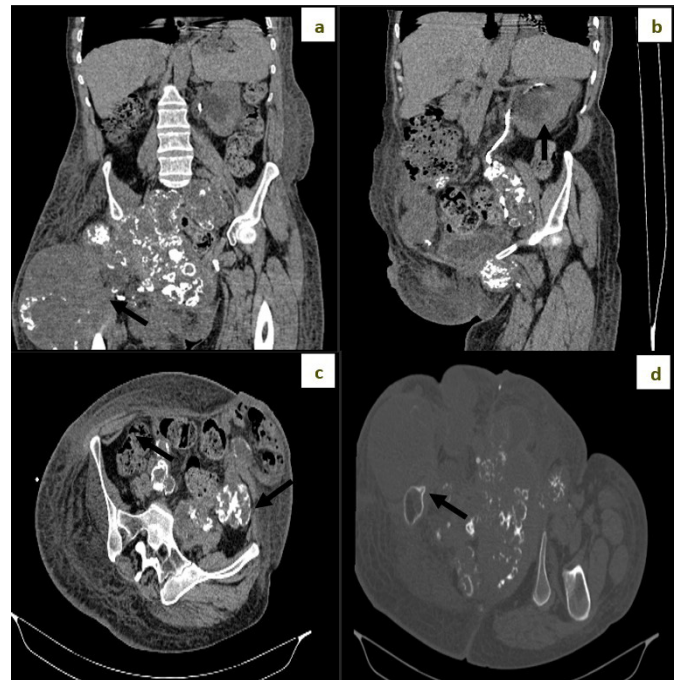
Abdominopelvic CT scan in coronal (a), sagittal (b), and axial (c) views, as well as axial view in bone window (d), reveals an infiltrative, lytic tissue process involving the right hip, extending to the upper part of the homolateral femoral diaphysis with pelvic extension (a), causing bilateral hydronephrosis (b). Intra-peritoneal mesenteric lymphadenopathy (c). Pedunculated bone exostosis in the upper third of the right femoral diaphysis (d).
